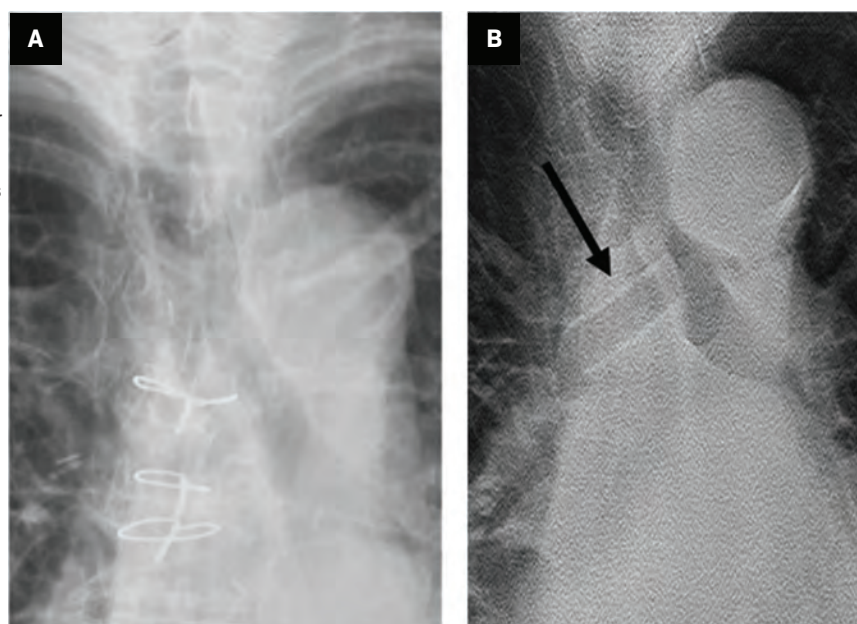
Adult lung transplant patient who underwent right mainstem bronchus stent placement for postprocedural bronchial stenosis. Conventional radiograph (A) shows poor visualization of the right mainstem bronchus owing to overlying anatomy and sternal wires. Digital tomosynthesis (B) demonstrates markedly improved visualization of the stented right mainstem bronchus (black arrow), which appears intact.
